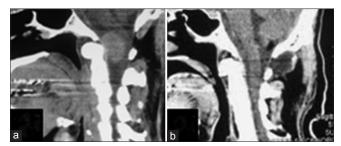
(a) Sagittal CT scan revealing a homogeneously enhancing tumor located anterior to the FM. The medulla is dislocated in a posterior direction. (b) Postoperative sagittal CT scan demonstrating a complete resection of the tumor via a suboccipital retrocondylar craniotomy in addition to a partial removal of the posterior arch of CI. The spinal medullary junction returned to the normal position
